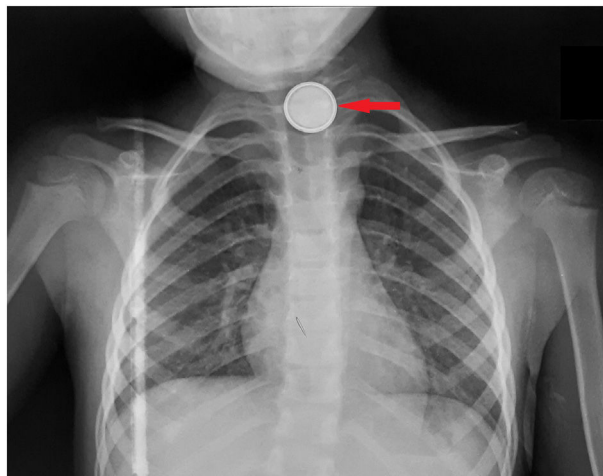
Chest X-ray showing a radiopaque foreign body with a double-ring sign.
